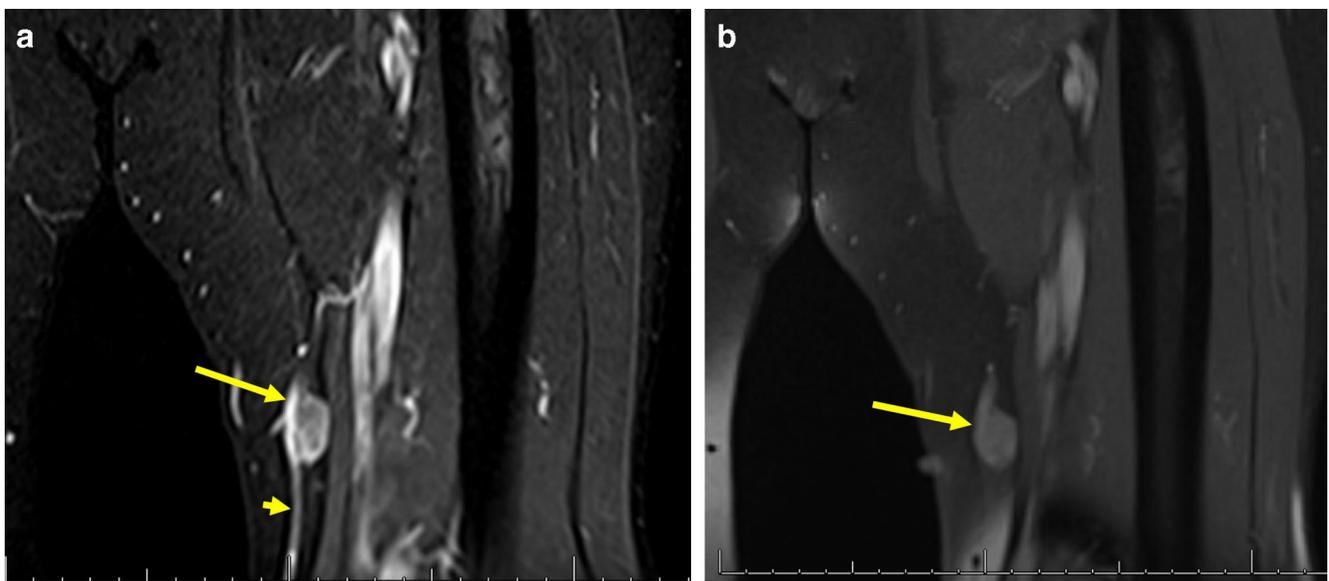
A 64-year-old man with a painful thigh mass. a Fat-suppressed coronal proton density-weighted MRI shows a 1.9-cm hyperintense subcutaneous nodule (*arrow*) arising from the greater saphenous vein (*arrowhead*). The relationship with the vein is suggestive of leiomyoma
